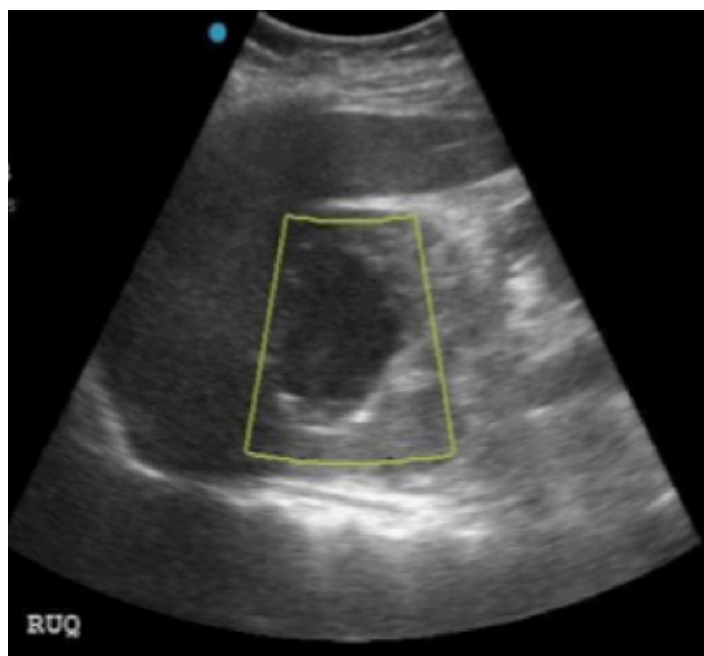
Upper quadrant mass seen on emergency physician-performed point-of-care ultrasound. Color Doppler demonstrating no flow (yellow box).
